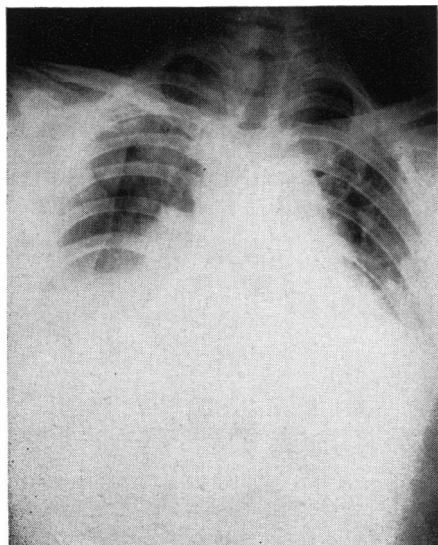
Portable chest roentgenogram taken on April 26 prior to institution of positive pressure breathing. A major portion of both lung fields is radio-opaque.
